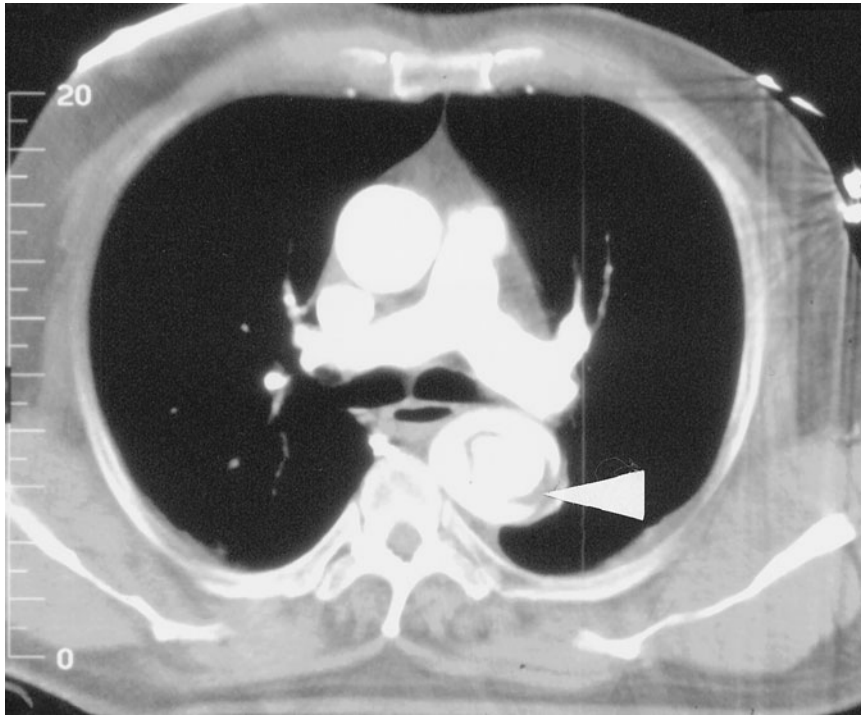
Axial image of CT arteriogram showing a nearly circumferential dissection flap (arrowhead) as a result of acute traumatic aortic dissection.
